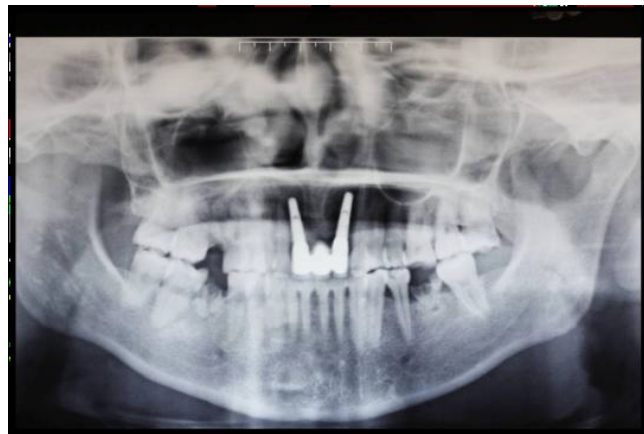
Panoramic X-ray of final treatment
